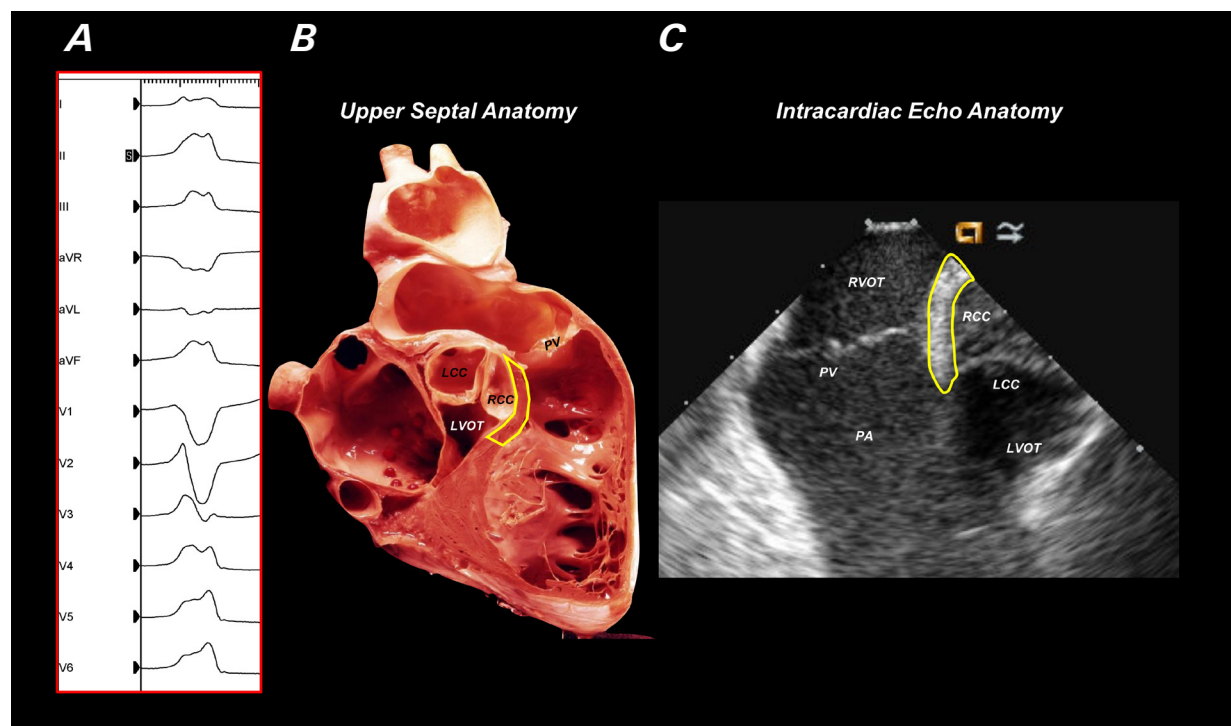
The anatomic relationship between different left and right ventricular structures when mapping intramural PVCs arising from the upper septum. A) A clinical PVC arises from the posteroseptal RVOT-RCC junction. B) Heart dissection shows the posteroseptal RVOT-RCC junction area, marked in yellow. C) Intracardiac echocardiogram shows the posteroseptal RVOT-RCC junction area, marked in yellow. Intracardiac echocardiography is important for clarifying anatomic relationships and determine optimal mapping and ablation vantage points.
